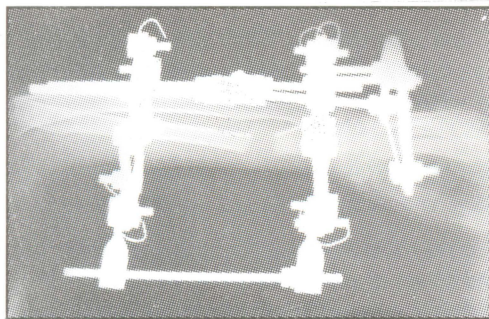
X-rays left wrist-showing reduction of the volar subluxation of the carpus and correction of volar tilt of the distal articular surface of radius.
